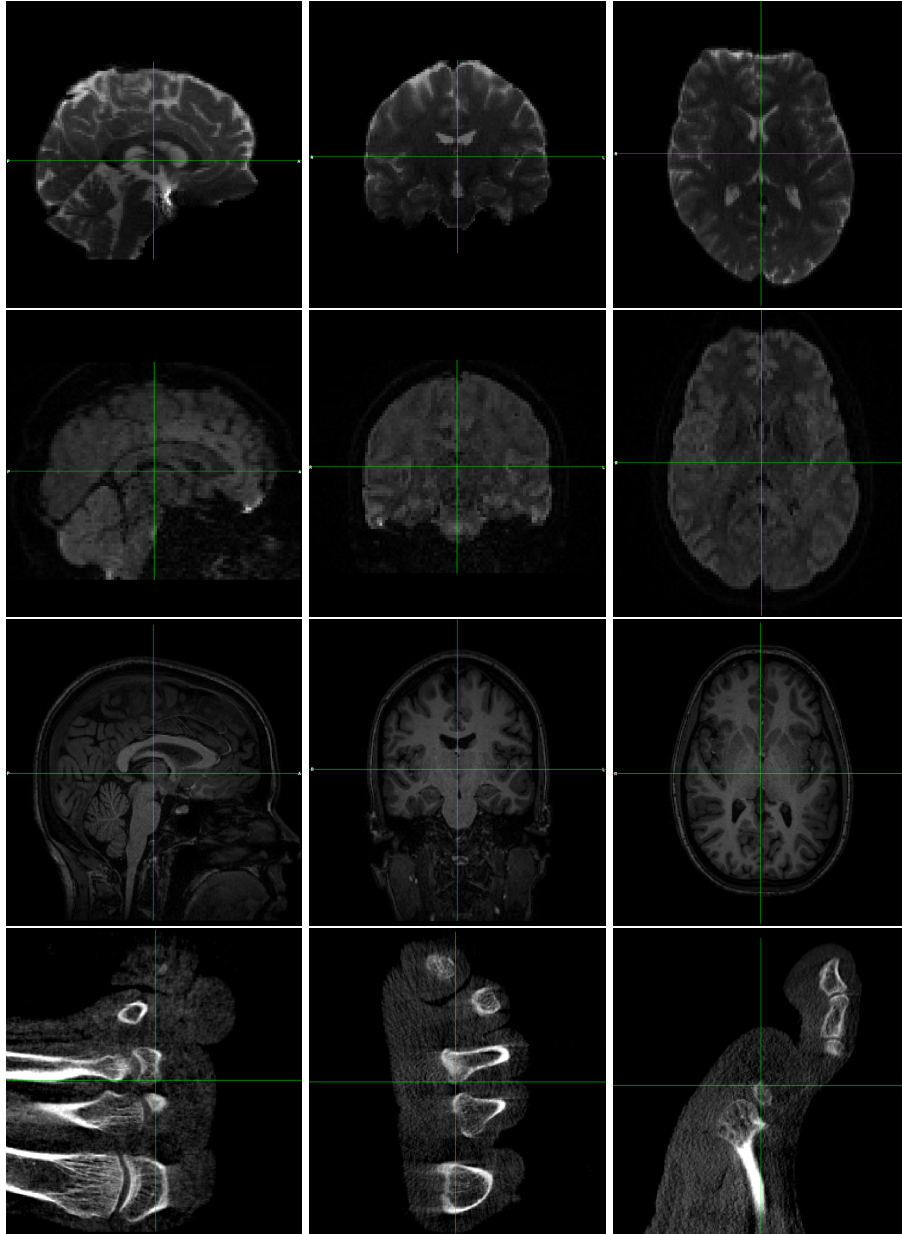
The four 3D medical images used in our experiments. Top to bottom: Three brain MR images with B_0 , B_{700} , and T_1 weighting, and a foot CT image. Right to left: The middle slices on the sagittal, coronal, and axial planes.
